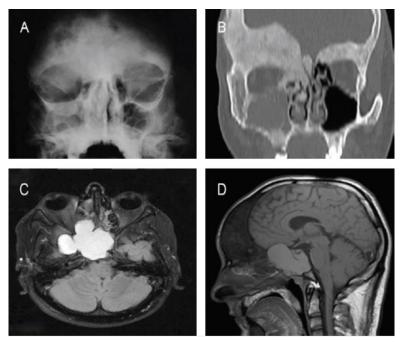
"Orbitofrontal and sphenoidal fibrous dysplasia: characteristic aspects of "ground glass" (A). CT scan appearance (B). MRI scan appearance: homogeneous well defined cystic lesion located in the sellar, suprasellar and parasellar areas", with compressive effect on the optic chiasm (C). T1WI showing the large cyst and frontal dysplasia (D) (from *Costea et al., 2015*)
